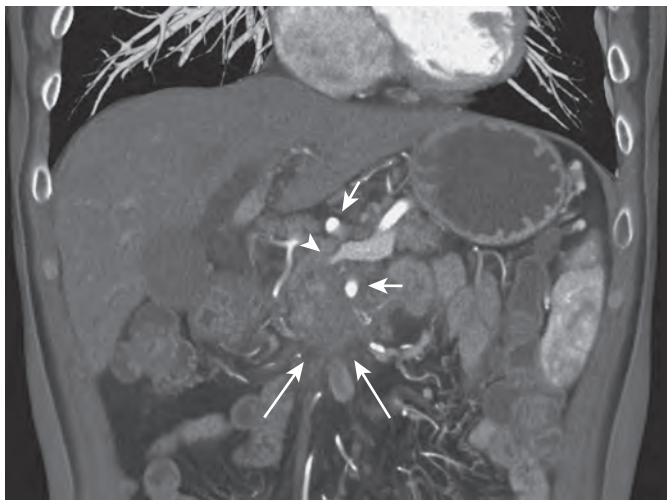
CT angiogram for the staging of pancreatic carcinoma. A large infiltrating pancreatic mass (large arrows) is encasing the superior mesenteric and common hepatic arteries (small arrows) and occluding the splenic vein (arrowhead). Note the perigastric collateral veins.
